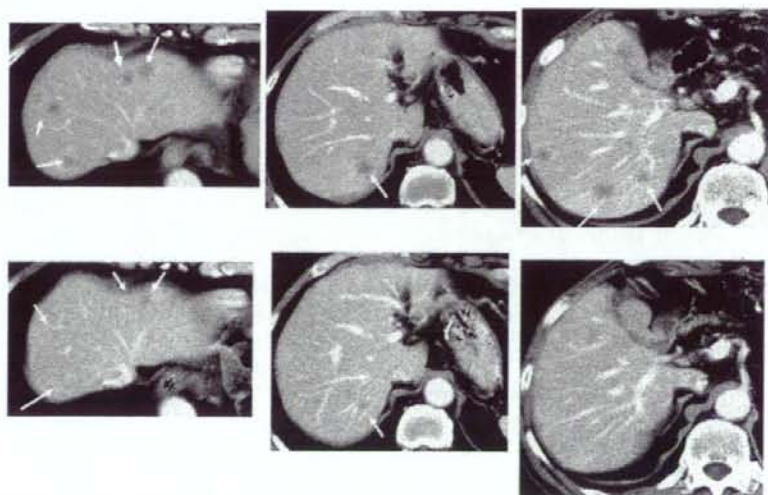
Serial CT scans. A 60-year-old male with pancreatic cancer who was treated with NK105 at a dose level of 150 mg/m². Baseline scan (upper panels) showing multiple metastasis in the liver. Partial response, characterized by a more than 90% decrease in the size of the liver metastasis (lower panels) compared with the baseline scan. The antitumor response was maintained for nearly 1 year [29].
